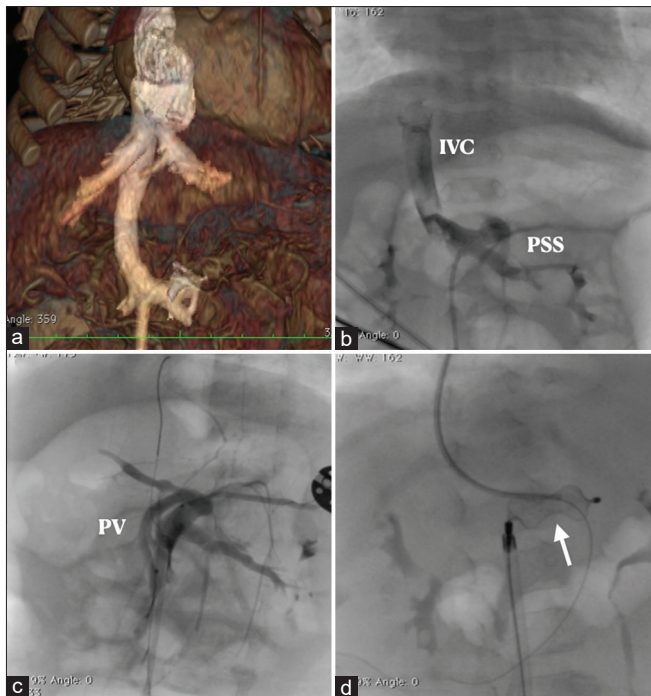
(a) Computed tomography angiogram of a child with absent ductus venosus during prenatal ultrasound examination showing portosystemic shunt (PSS), (b) cine angiogram showing PSS, (c) balloon occlusion angiogram showing intrahepatic portal radials. (d) A vascular plug (white arrow) is being deployed in the channel of the PSS. PSS: portosystemic shunt, PV: portal vein, IVC: inferior vena cava
